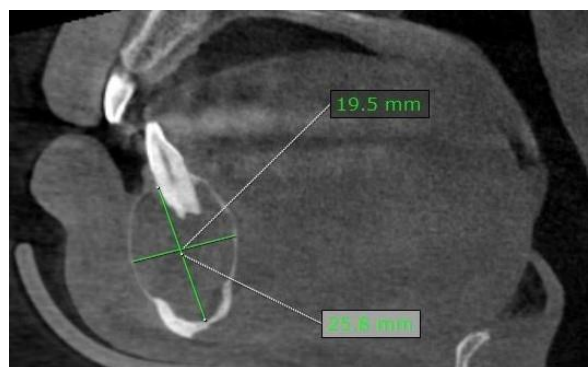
CT scan – Bucco lingual cortical plate expansion
